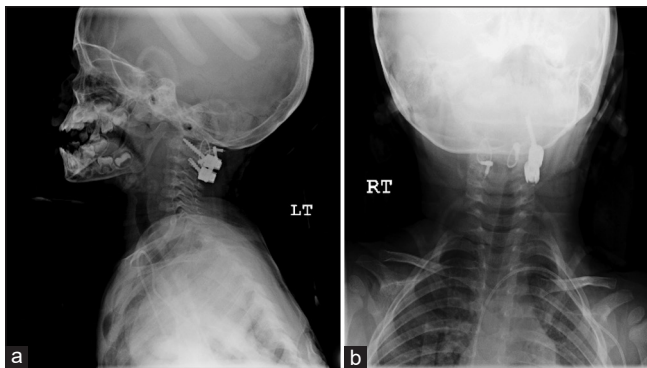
Postoperative lateral (a) and anteroposterior (b) cervical spine radiograph showing atlantoaxial instrumented fusion with sublaminae wiring and autograft placement on the right and lateral mass and pars screw fixation on the left
